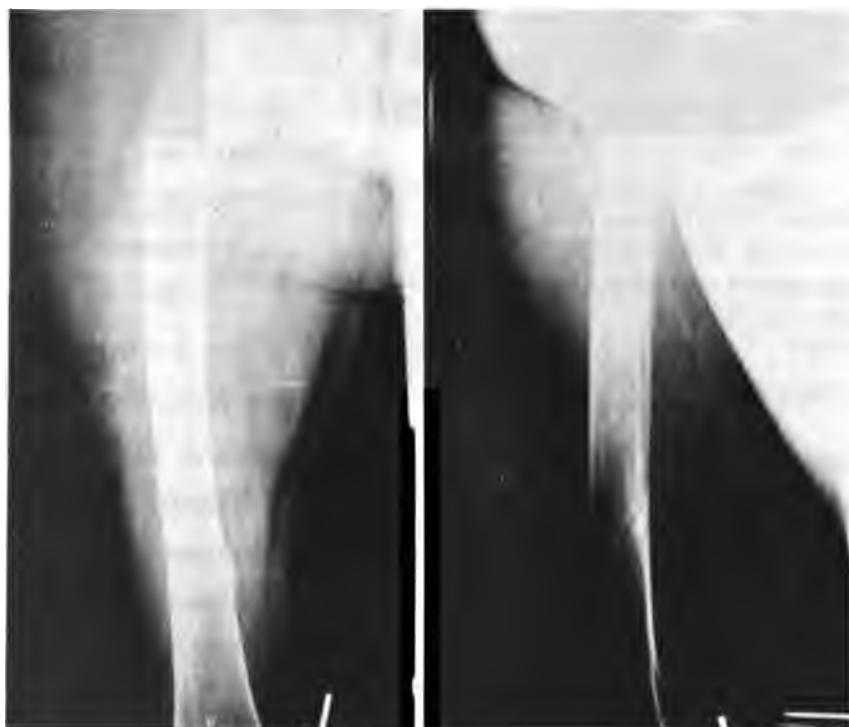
Left*, A-P roentgenogram of 32-year-old man with distal femoral fracture treated with cast-brace 3½ weeks after injury. *Middle and right*, A-P and lateral roentgenogram of healed fracture 14 weeks after injury.
